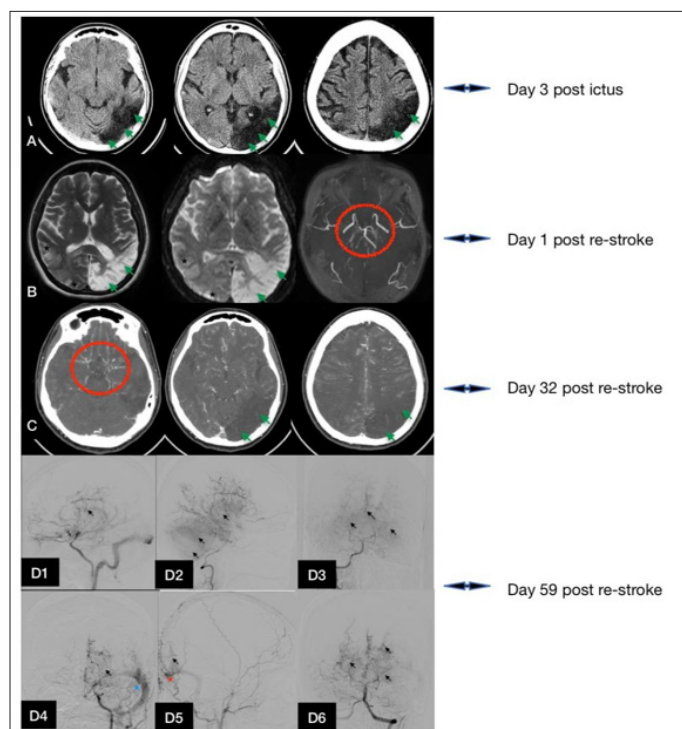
Plain Cranial CT Scan day 3 post ictus (A) showing areas of infarction/hypodensities on the left parieto-occipito-temporal region (green arrows), Cranial MRI with MRA day 1 post re-stroke (B) showing left temporo-occipital old infarction/encephalomalacic changes (green arrows) and right temporo-occipital cortical laminar necrosis (asterisks), stenotic vessels (encircled red); Cranial CT Angiogram day 32 post re-stroke (C) showing old infarction at the left temporo-occipital region (green arrows) with Moyamoya vessels (encircled red). Digital Subtraction Angiography Day 59 post re-stroke (D) showing Puff-of-smoke or Moyamoya vessels (black arrows). Dural Arteriovenous Fistula of Right Occipital Artery and Torcula (red arrow). Dural Arteriovenous Fistula of Left Temporal Artery and Left Sigmoid Sinus (blue arrow). Left ICA Injection (D1, D4), Right ICA Injection (D2), Right Vertebral Artery Injection (D3), Right ECA Injection (D5), and Left Vertebral Artery Injection (D6).
